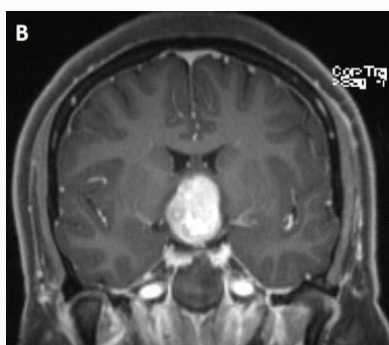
Initial MRI: Sella and suprasellar structures.
